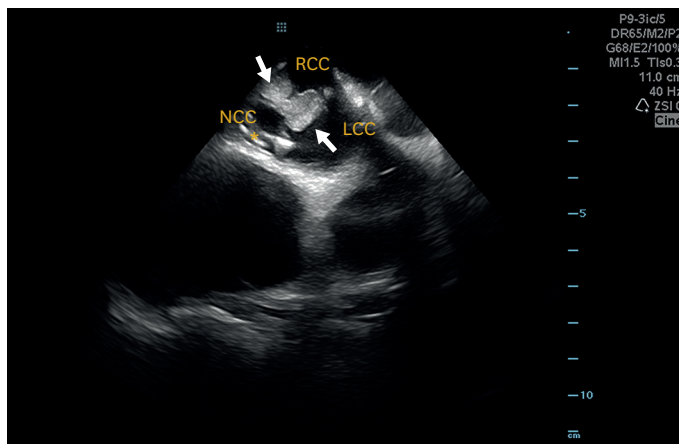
Intracardiac echocardiography showed 2 oscillating mobile vegetations attached to the leaflets of the aortic bioprosthetic valve and the perivalvular aortic root fluid (asterisk). LCC: left coronary cusp, NCC: non coronary cusp, RCC: right coronary cusp.
